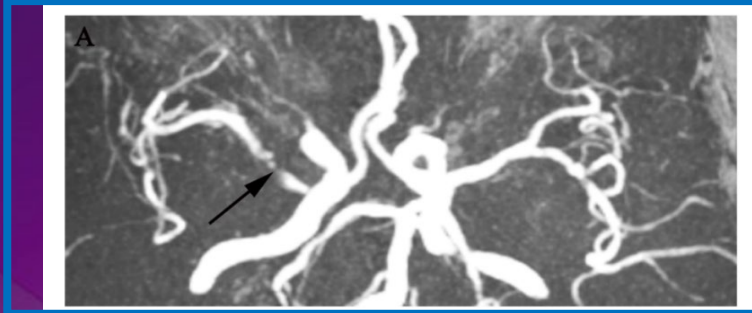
Representative MR images delineating enhancement index measurement. A 60-year-old man with acute stroke showed severe right MCA stenosis on MRA (A, white arrow). After matching pre- (B and D) and post-contrast T1w images (C and E) at the most severe narrowing site, the plaque enhancement index was 48.74%.
